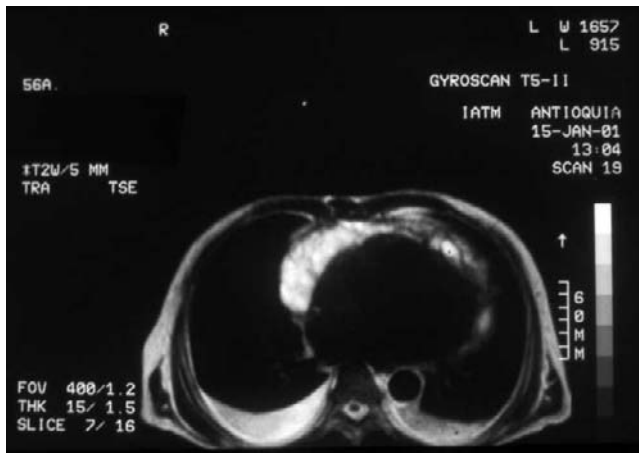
MRI obtained before therapy. Bilateral pleural and pericardial fluid accumulation with honeycombed partitions are present.
